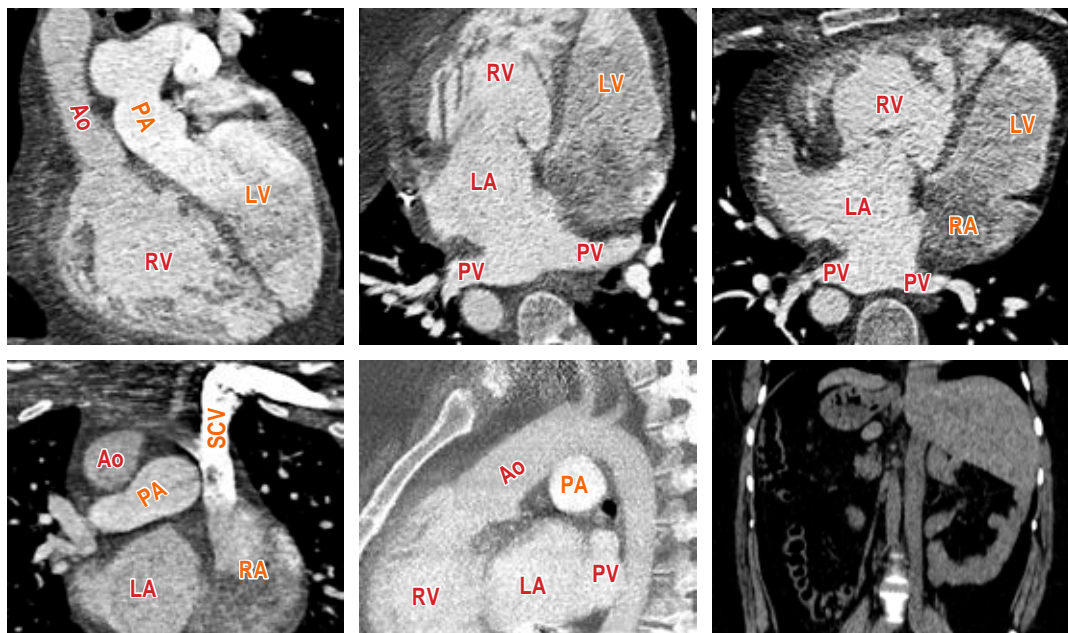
Cardiac computed tomography: viscerotrial *situs inversus*: left-sided inferior cava vein, right-sided abdominal aorta, right-sided liver, left-sided stomach, mirror-image atrial arrangement with L-looping of ventricles. Ventriculoarterial discordance: a right-sided morphologic right ventricle with an arising aorta and a left-sided morphologic left ventricle with an emerging pulmonary artery. Atrioventricular discordance: right-sided left atrium receiving pulmonary vein drainage communicates with the tricuspid valve to right ventricle, while left-sided right atrium receiving cava vein drainage communicates with the mitral valve to left ventricle. RV = right ventricle. LV = left ventricle. LA = left atrium. RA = right atrium. Ao = aortic. PA = pulmonary artery. PV = pulmonary vein. SCV = superior cava vein.
